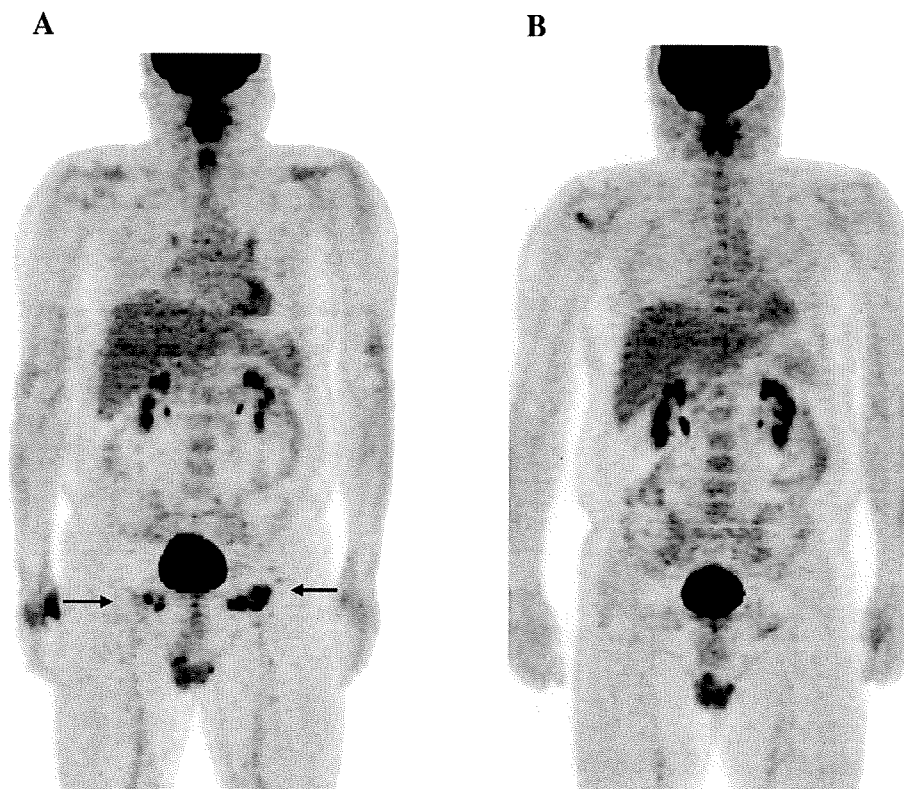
FDG uptake (A) on admission and (B) after steroid therapy. The FDG uptake in the bilateral inguinal regions (arrows) disappeared 4 weeks after the steroid therapy.
